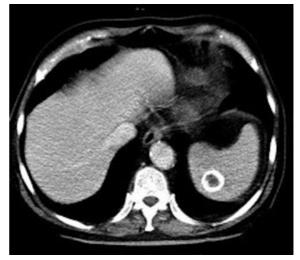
Hydatid disease. CT, venous phase. A small lesion with low attenuation values and thick calcified walls (Courtesy of Charikleia C Triantopoulou, M.D., Department of Radiology, Konstantopouleion General Hospital, Athens, Greece)
